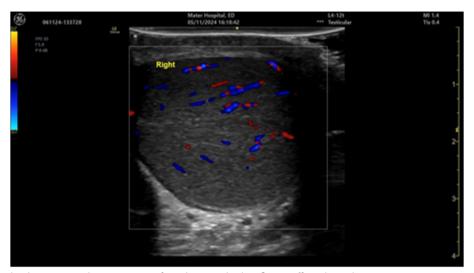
Repeat Doppler showing complete restoration of circulation and colour flow to affected testicle
